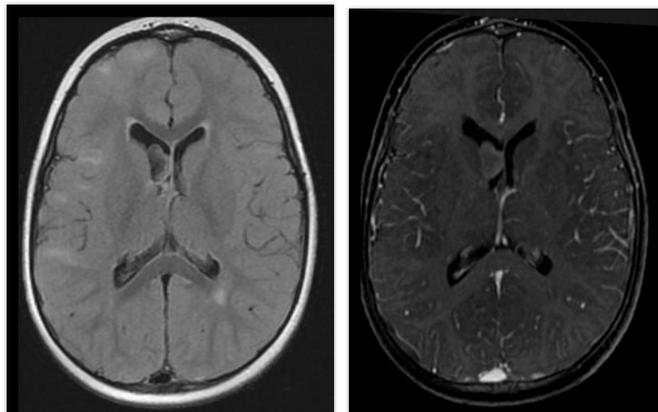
MRI axial sections, A and C T2 FLAIR; B and D T2 GRE show subependymal nodules (o) in the body of the lateral ventricles, some calcified. There are also rare areas of cortical thickening (arrow), which assume a triangular appearance, associated with hypersignal in the white matter, with loss of cortical/subcortical differentiation, suggesting tubercles. Imaging findings in a 23-year-old male patient diagnosed with Tuberous Sclerosis.
